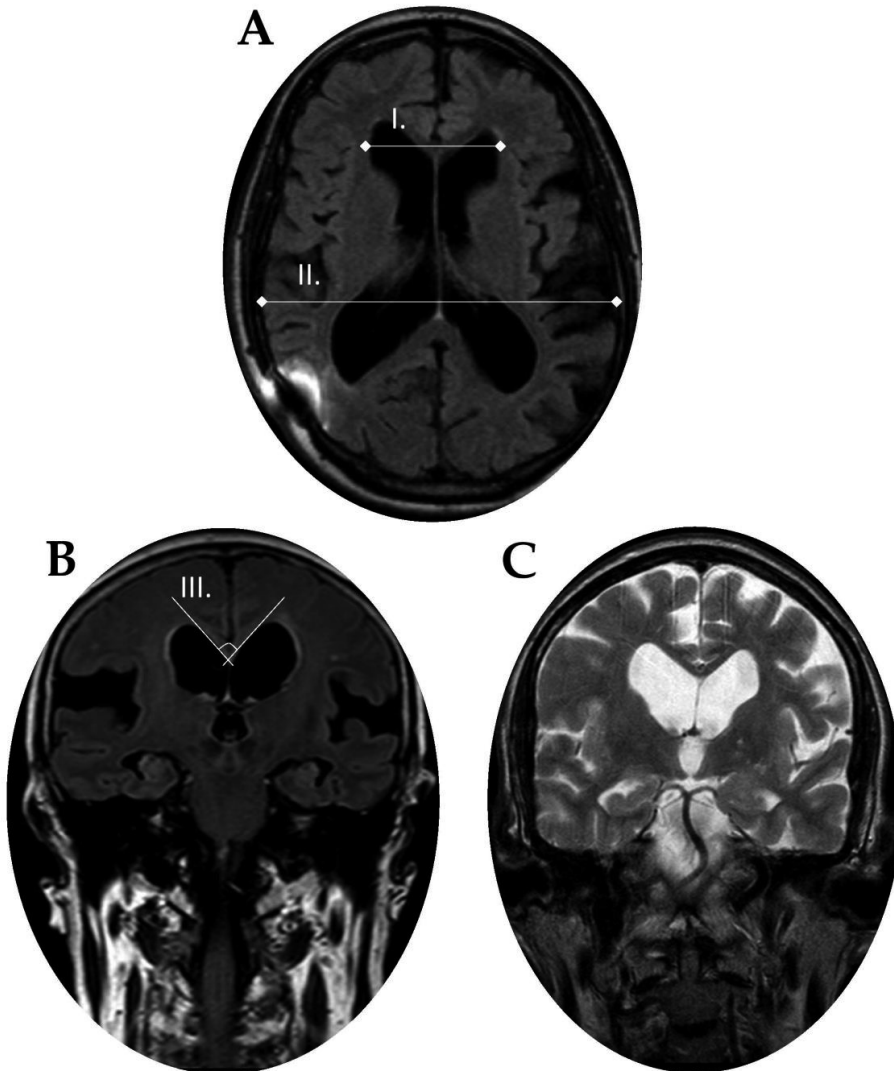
The radiological presentation of iNPH in two patients (AC, B) using axial (A) and coronal (B and C) magnetic resonance imaging. Line I, maximal width of the frontal horns of the lateral ventricles; line II, maximum inner diameter of the skull; line III, callosal angle; B, disproportionately enlarged subarachnoid space hydrocephalus (DESH); C, non-DESH.
